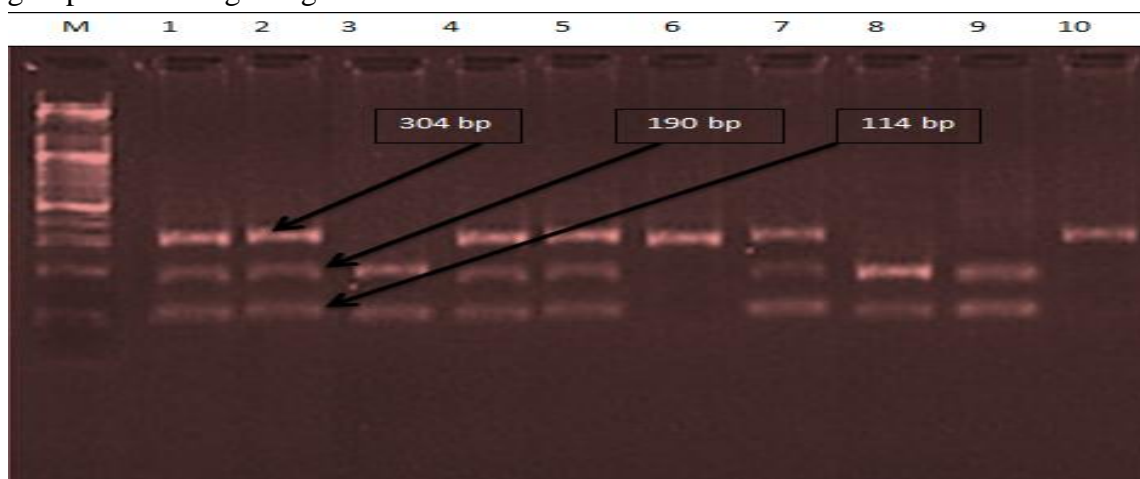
PCR-RFLP and PAGE of -511 C/T promoter of IL-1B gene showing three genotypes CC, CT, and TT in different bands length (304, 114, and 190 bp).
